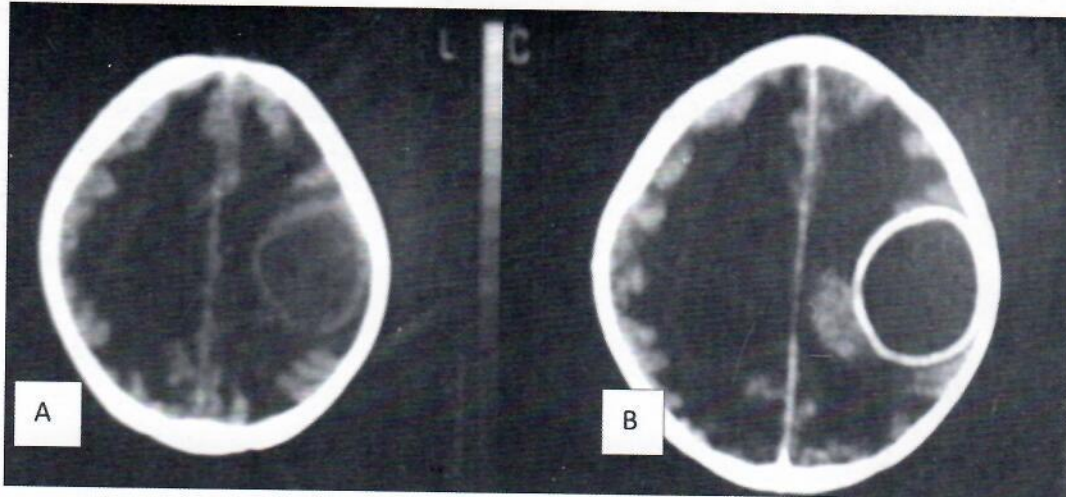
Axial non-enhanced cranial CT showing a roundish hypodense mass with slightly hyperdense rim in the left parietal lobe. The mass shows avid ring enhancement post contrast injection (B) consistent with an intracranial abscess.
